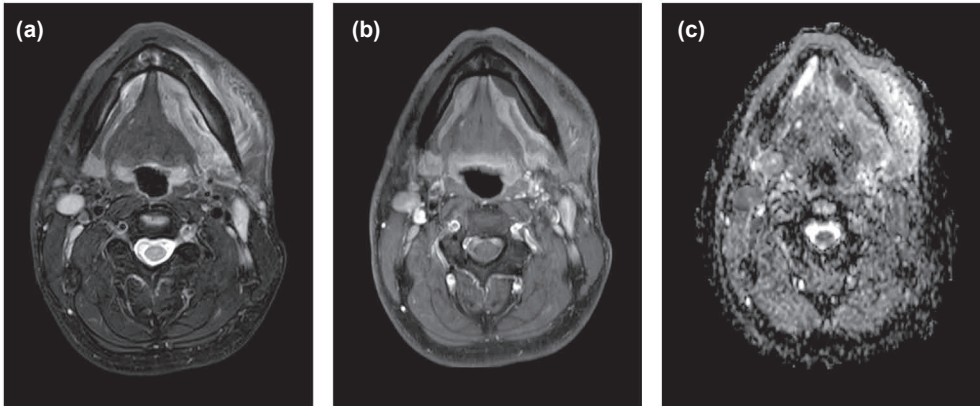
Submandibular space subperiosteal abscesses. A 32-year-old man presented with left submandibular space swelling and subsequent dental extraction. Axial MRI slices (a, T2-weighted Dixon water; b, gadolinium-enhanced T1-weighted Dixon water; c, apparent diffusion coefficient from diffusion weighted imaging) demonstrated non-enhancing collections with restricted diffusion surrounded by abnormal tissue enhancement on the medial aspect of the body of the mandible, consistent with subperiosteal abscesses. Modified from study II.
